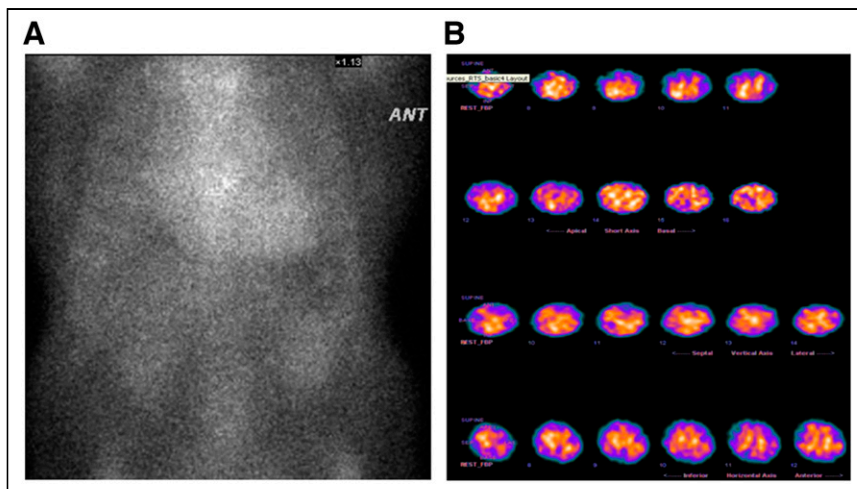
Blood pool on ^{99m}Tc -pyrophosphate scintigraphy. (A) Anterior planar image with Perugini score of 2. (B) SPECT images demonstrating no evidence of myocardial uptake. ANT = anterior.
